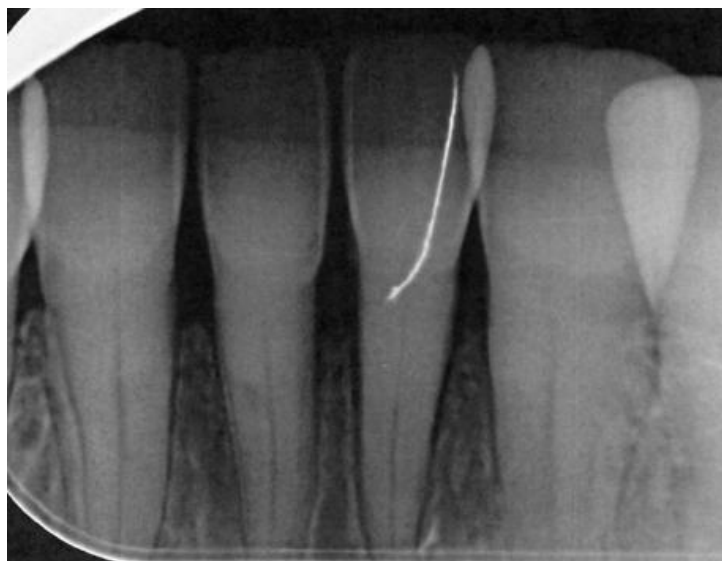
Radiograph showing the regression of the disease three months after using Clean and Seal protocol was implemented.
